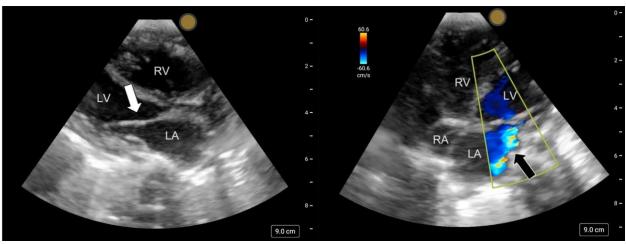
Parasternal long axis (left) depicting restricted movement and abnormal morphology of the anterior mitral valve leaflet (white arrow). Apical four chamber (right) with visualization of the left atrium (LA), left ventricle (LV), right atrium (RA), and right ventricle (RV) with a mitral regurgitation jet on color flow Doppler (black arrow).
